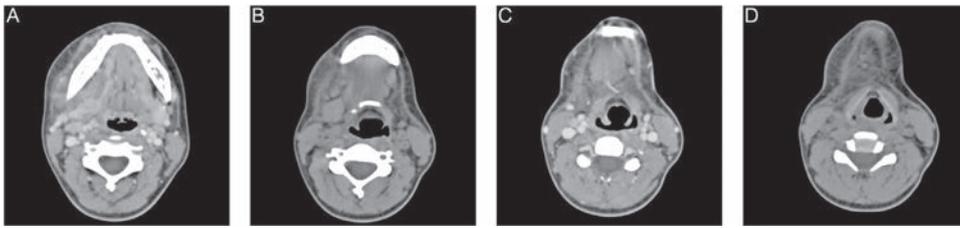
(A–D) Cervico-thoracic CT scan with and with-out contrast fluid showing the extension of cellulitis, the occlusion of esophagus and the deviation of trachea.
